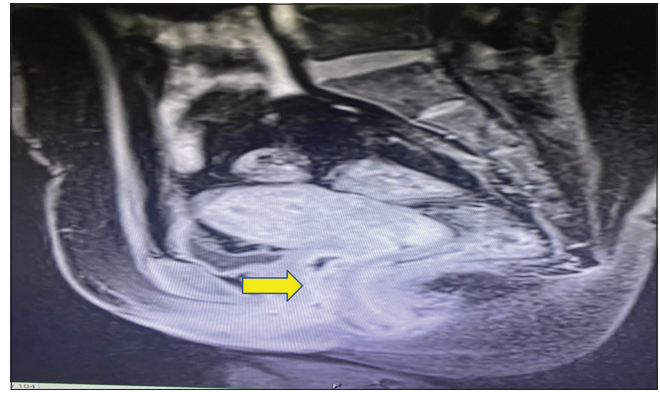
T1-weighted image of the cervix
